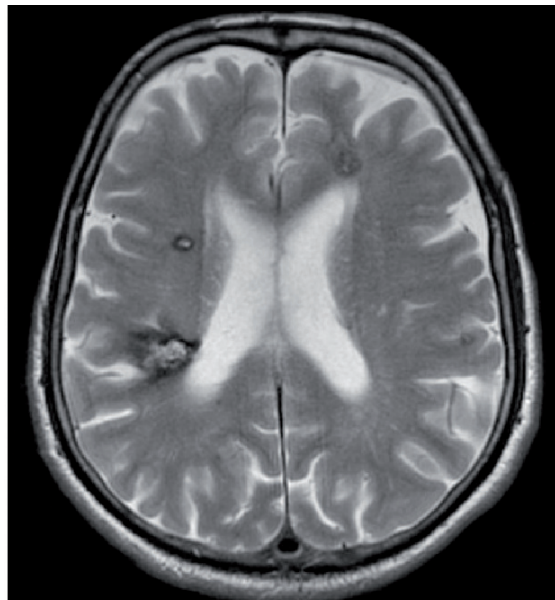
Type II cavernoma in T2-weighted sequence with a more clearly demarcated hemosiderin zone.
